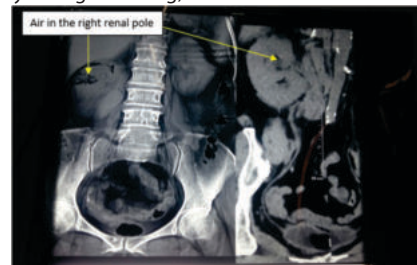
Computed Tomography (Abdomen and pelvis)
